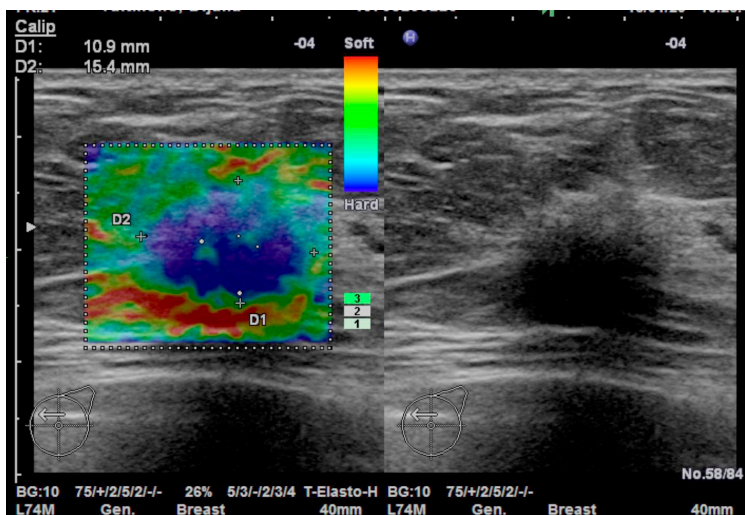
Ultrasonogram of breast pathological mass ~17mm. Elastography shows hard tissue (blue color)
